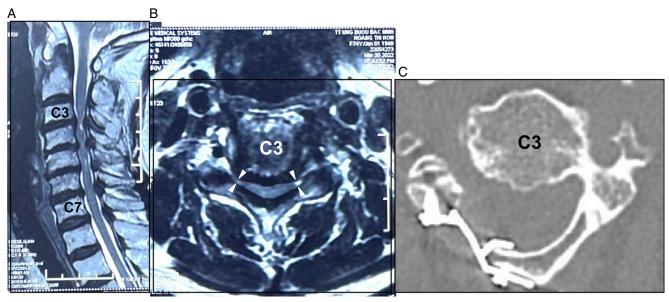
(A): The preoperative sagittal MRI of a 52-year-old showed four-level cervical spondylotic myelopathy (C3–C7) with T2W intrinsic cord edema at C3–C4. (B): The preoperative axial MRI at C3–C4 showed spinal cord compression anteriorly, and foraminal stenosis. (C): The postoperative axial CT showed the laminoplasty defect.
